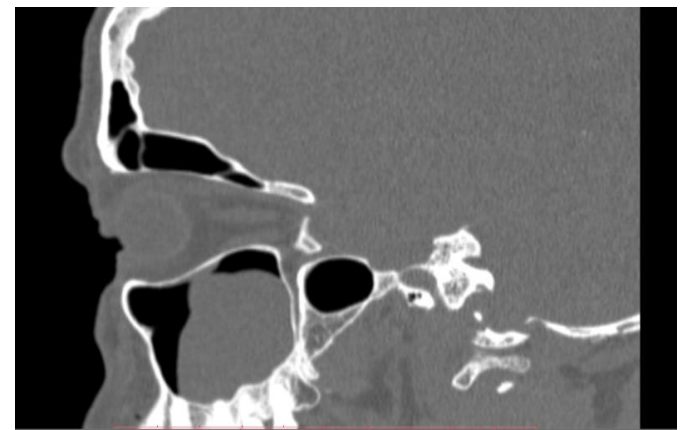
Sagittal reformatted CT of the right antrum showing an oval isodense lesion with a superior convex margin and no obvious bony erosion.
